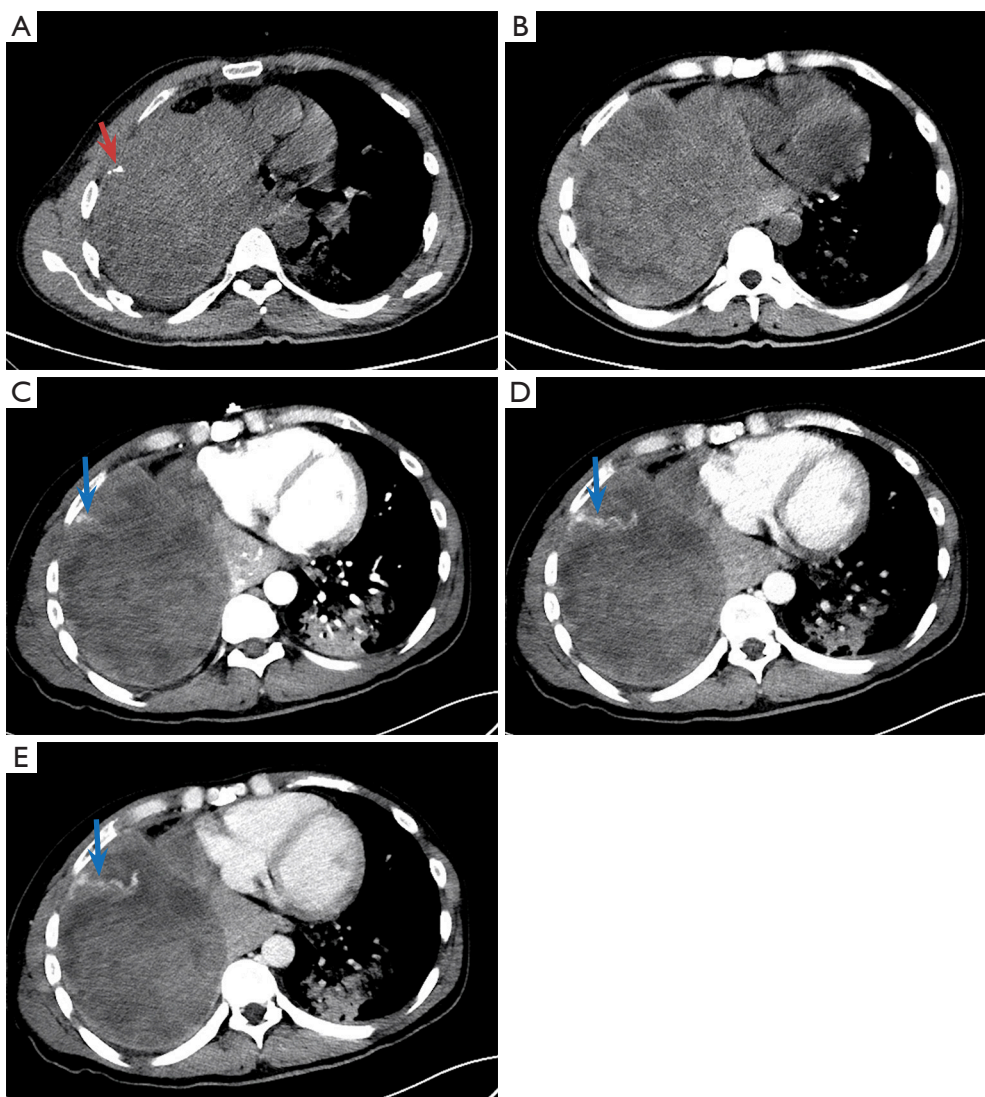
Axial chest computed tomography (CT) scan showing a mass in the right pleural cavity affiliated with the chest wall, with narrowing of the spacing of adjacent ribs. (A) The red arrow represents calcification located primarily on the periphery. (B) No enhanced phase was observed. (C) Arterial phase. The blue arrow represents the feeding vessel. (D) Venous phase. (E) Delay phase. Contrast-enhanced CT showed slight uneven progressive enhancement (the scanning times for the arterial phase, venous phase, and delay phase were 20 to 25 s, 40 to 50 s, and 2 min, respectively). The injection rate of the contrast media was 3.0 mL/s).
